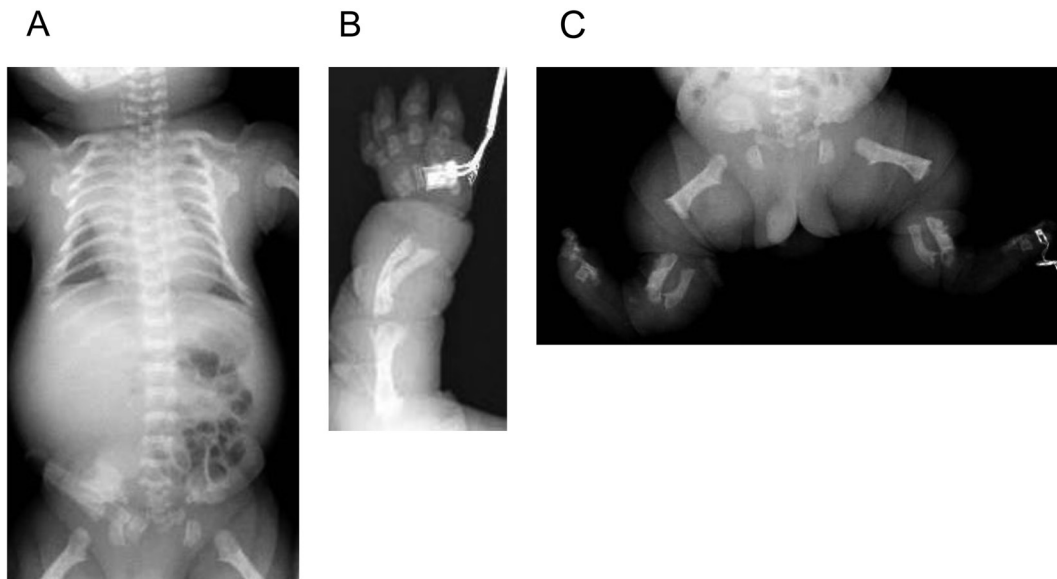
Bone radiographs at birth. The patient's bone findings are more severe than those normally observed in achondroplasia; the patient also exhibited other unusual bone features. (A) The thorax is slightly smaller, but there is no finding of significant hypoplasia as seen in TD. (B) (C) Shortened extremities, bowing of the tibia and fibula, and pelvic hypoplasia are seen.
